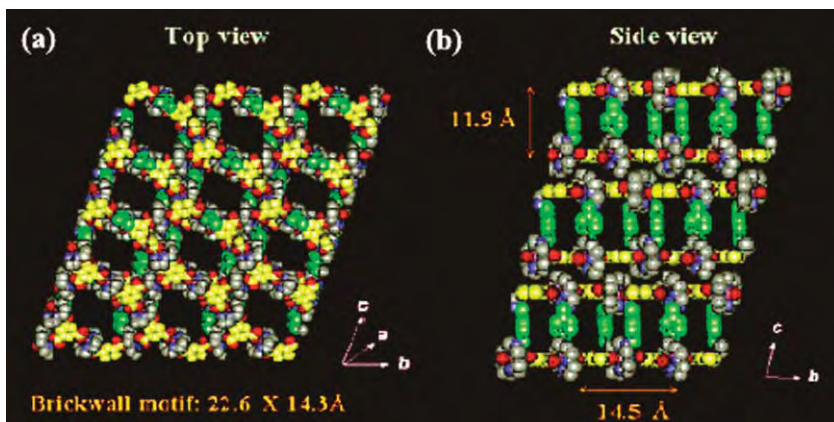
X-ray structure of BOF-1 (13). (a) Top view showing 2D layers of brick-wall motif. (b) Side view showing pillared bilayer structure [thickness of bilayer, 11.91(1) Å].
